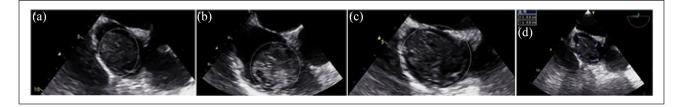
Transesophageal echocardiography (TEE) imaging series: (a-c) 90°, 120°, and 180° bicaval views, respectively, with a circle encapsulating the large right atrial thrombus, demonstrating a heterogeneous appearance; (d) 90° bicaval view demonstrating the dimensions of the right atrial thrombus before initiation of therapy.
